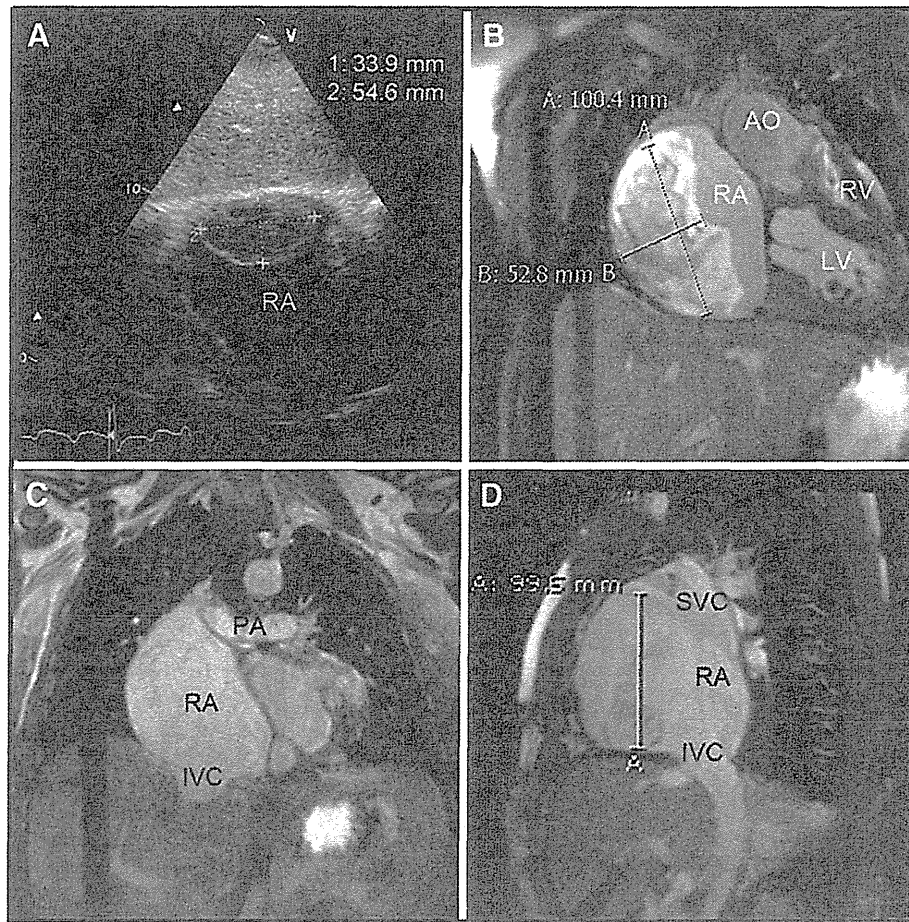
A thrombus in the right atrium (RA) was present two years ago when the patient was in atrial flutter (echocardiogram shown in 1A) which increased in size enormously after two years that the patient had been in atrial fibrillation (cardiac magnetic resonance 1B to 1D) (see text for details). RA, right atrium; RV, right ventricle; LV, left ventricle; AO, aorta; SVC, superior vena cava; PA, pulmonary artery; IVC, inferior vena cava.
